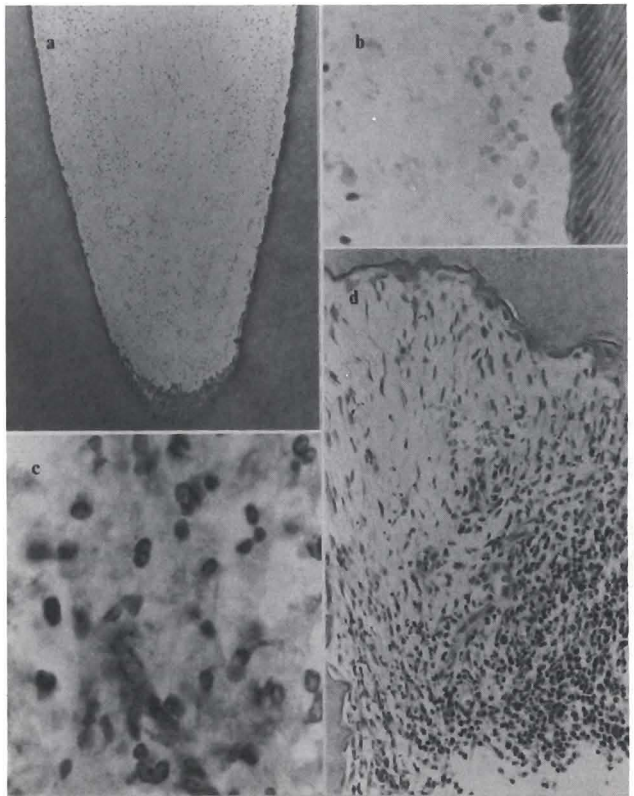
Clinical observations: M.V., two-year, one-month-old boy fell on cement sidewalk. Tooth F was intruded. One week later, the boy fell, again striking F. Tooth F was mobile; sensitive to percussion, but not to palpation; unchanged color; coronal fracture; and gingival swelling as seen in the clinical photograph. Increased PDL space and periapical radiolucency were also observed. The tooth was extracted eighteen days after original injuries.
